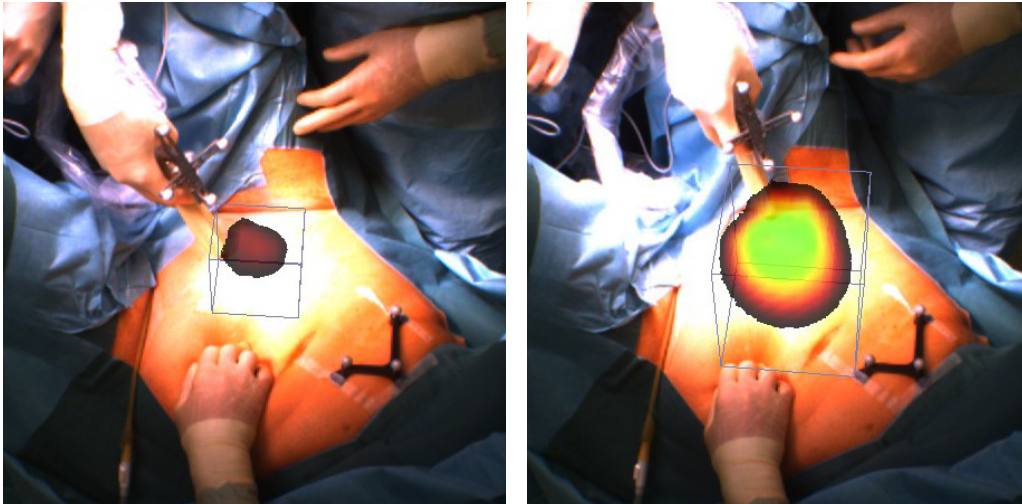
AR visualization during a Freehand SPECT acquisition (declipseSPECT with gamma probe). Color augmented over the video image shows the amount of information collected on the region: green/yellow = sufficient information, red/black = insufficient information, white wireframe visualizes the computation volume whose size is adjusted on-the-fly during the acquisition.
